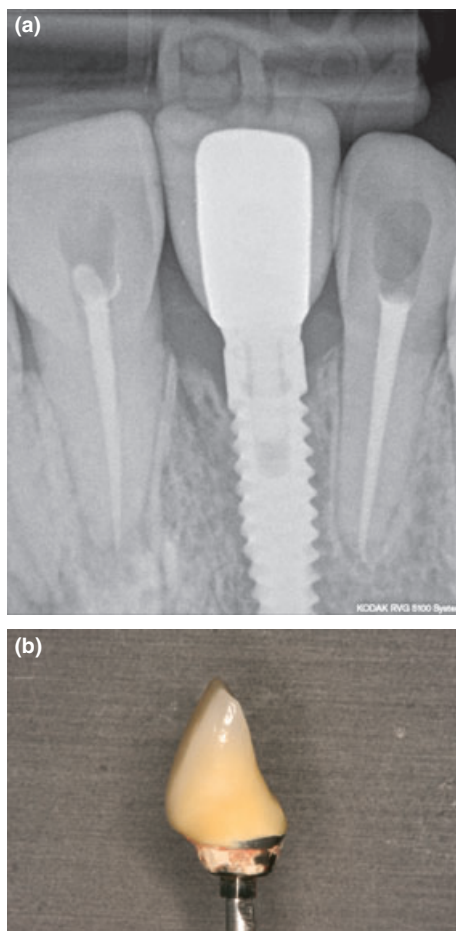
(a) Radiographic image of restoration without visible cement remnants proximally and buccally. (b) Cement on mesial and buccal sites of the removed restoration.
